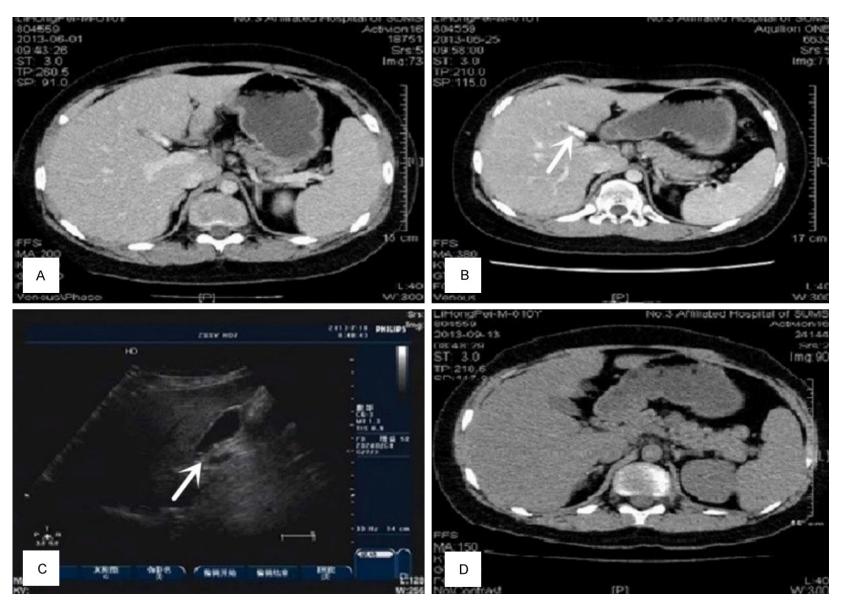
A. Computed tomography (CT) image showing no abnormalities were observed in gallbladder; B. CT image showing reduction in the volume of gallbladder and multiple circular high-density shadow in the capsule measuring approximately 17 × 6 mm; C. Ultrasonographic examination revealing the presence of gallbladder sediment with a hyperechoic image measuring about 5 × 6 mm in the gallbladder; D. CT image showing no abnormalities were observed in gallbladder.
